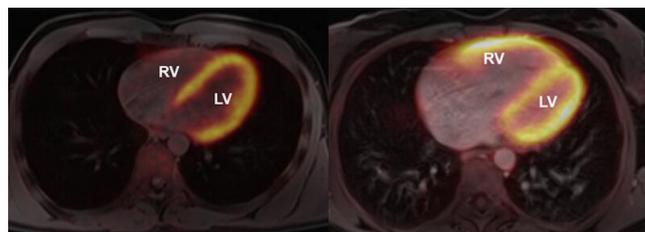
Left scan—PET/MRI scans of healthy control's heart (SUV_{RV} 0.3, SUV_{LV} 2.5). Right scan—patient's heart with highly elevated glucose uptake in RV wall in case of pulmonary arterial hypertension presence (SUV_{RV} 4.2, SUV_{LV} 3.1). LV, left ventricle; RV, right ventricle; SUV, standardised uptake value.
